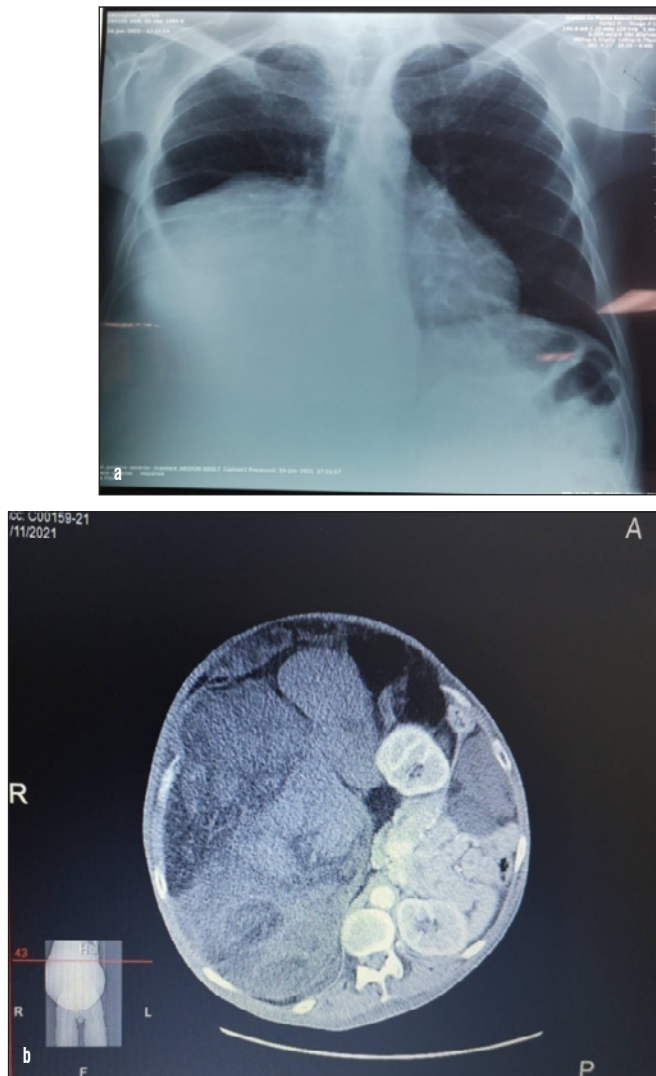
Preoperative chest X-ray showing right diaphragmatic elevation due to the tumor size (a) and preoperative computed tomography (CT) scan of the abdomen showing a giant solid mass (b)
